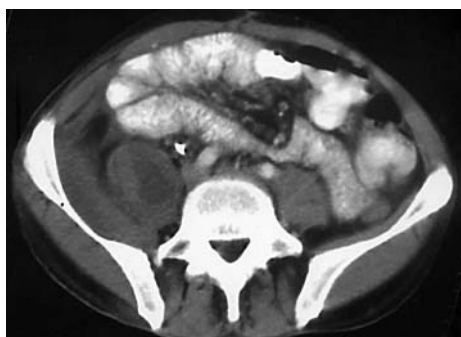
Computed tomogram of the abdomen and pelvis revealing a right psoas abscess.
